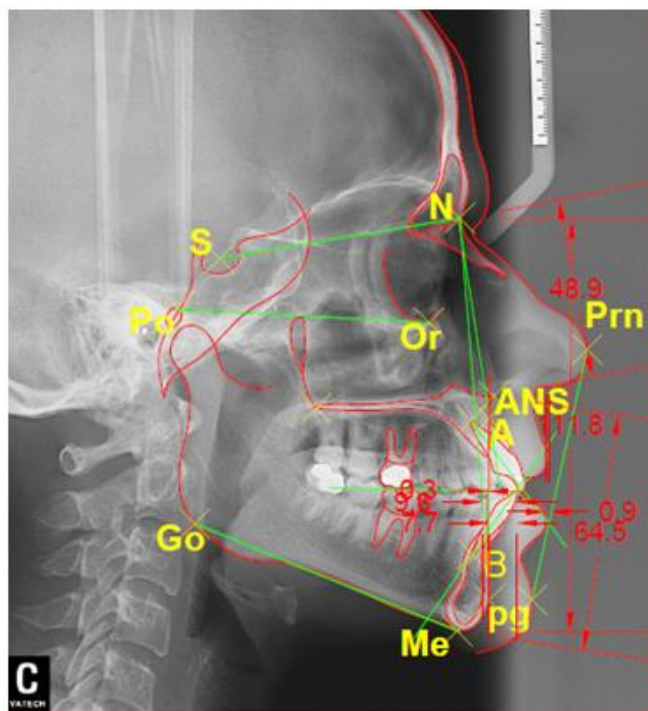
Angular measurements in cephalometric radiograph
